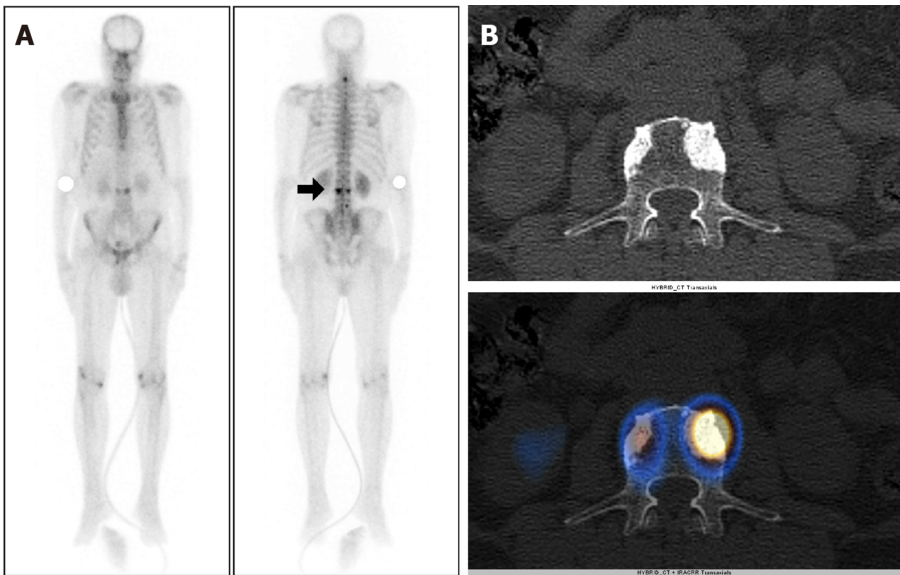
A 74-year-old male, with a newly diagnosed case of carcinoma of the prostate [Gleason's Score 7 (4 + 3)] with serum prostate-specific antigen level 491 ng/mL and underwent whole body bone scintigraphy. A: ^{99m}Tc methylene diphosphonate Whole body planar images show focal increased tracer uptake involving the cervical and lumbar vertebrae (arrow) raising the suspicion of metastatic disease; B: Axial computed tomography (CT) and fused single photon emission computed tomography (SPECT)-CT images show tracer localization to sclerotic lesion involving L3 vertebrae suggestive of metastatic disease. No metastatic disease was seen in pelvic bones on SPECT-CT.
